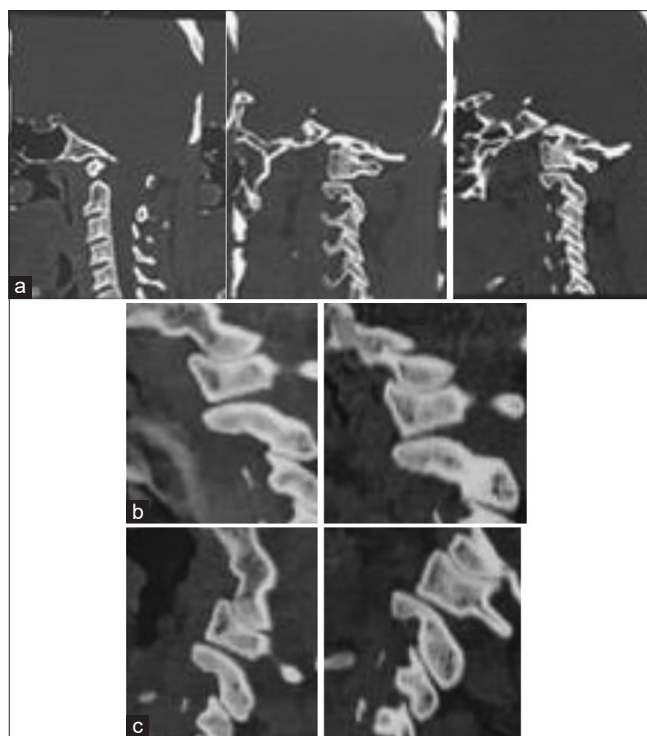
(a) Computed tomography (CT) Craniovertebral (CV) junction neutral, (b) CT CV junction extension, (c) CT CV junction flexion
